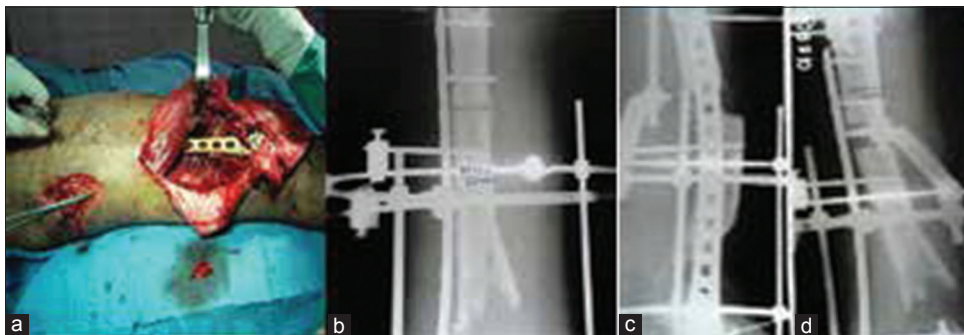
Case 2: Peroperative photograph and x-rays of thigh showing (a) removal of tubular external fixation and lateral two K-wires, wound debridement (b) fixation with distal femoral metaphyseal plate (c) stabilization with Ilizarov ring fixator and corticotomy upper femur (after 8 weeks of distal femoral metaphyseal plate) (d) bone transport started after 10 days of corticotomy
